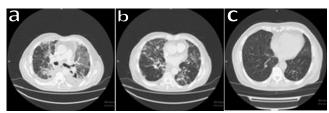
Areas with slightly ground glass density and fibrotic recessions extending to the pleura observed in both lungs (a and b). On control Thoracic CT, near-complete improvement in lung parenchyma was detected (c)
